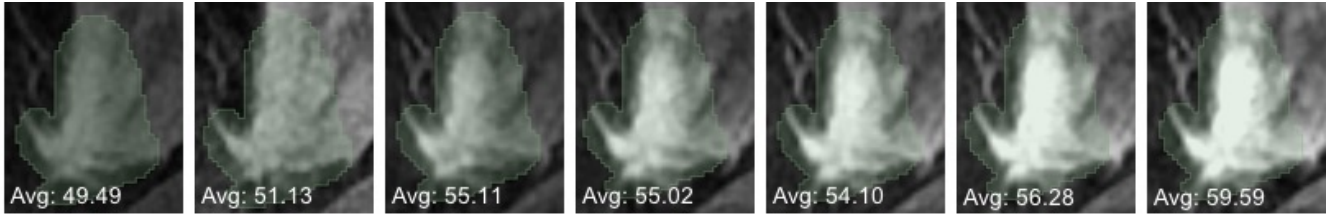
An example of a DCE-MRI sequence, depicting the manually segmented ROI in green. The average gray level intensities for each ROI are also shown.
